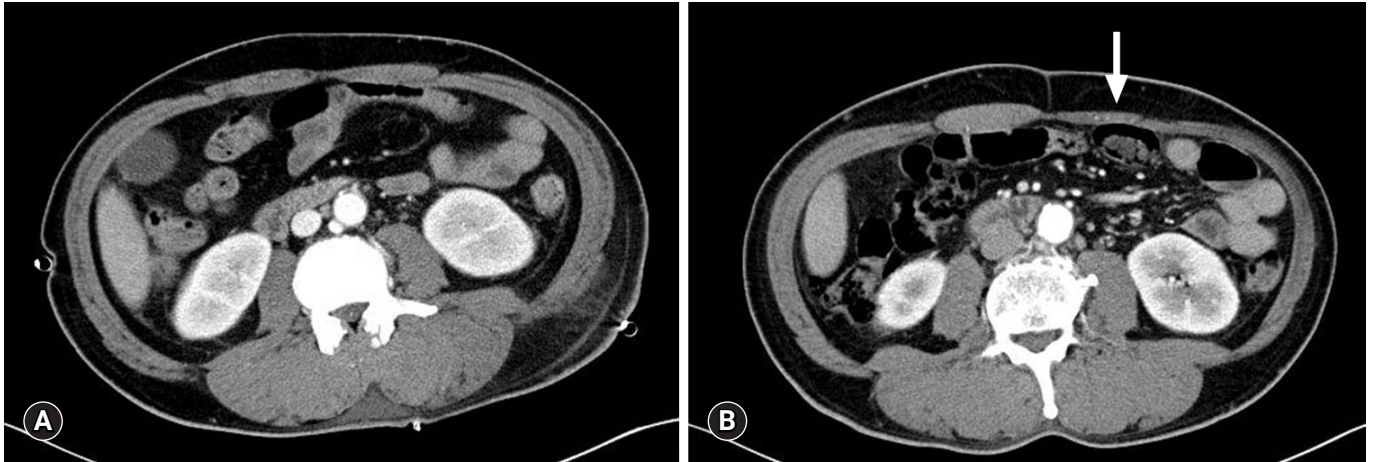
(A) Preoperative abdominal computed tomography (CT) scan shows normal symmetric rectus abdominis. (B) Follow-up CT scan reveals a flattening of the left side rectus abdominis (arrow).
